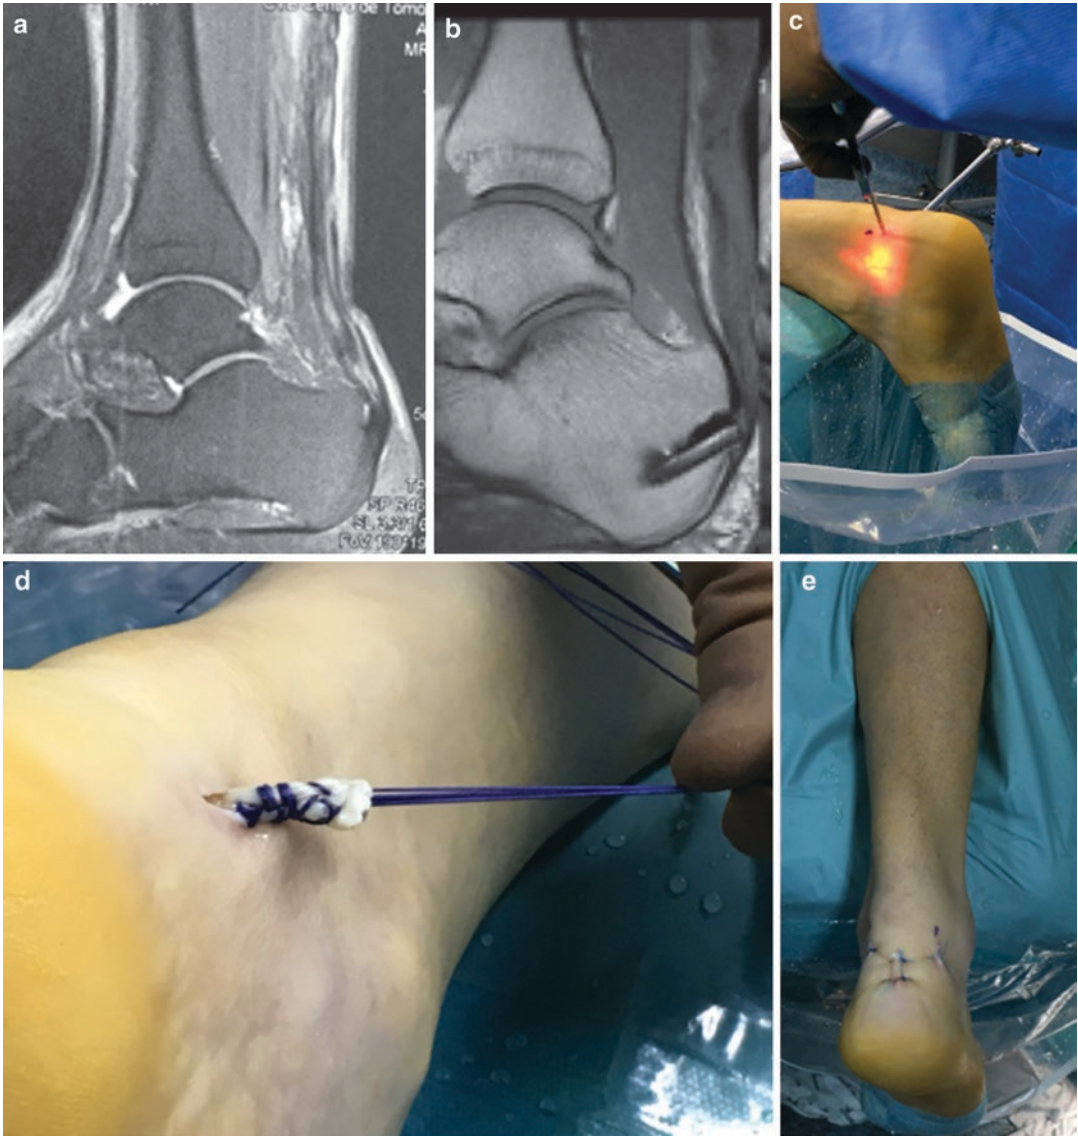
(a) MRI showing complex Achilles rupture; (b) MRI after Flexor Hallucis Longus Transfer (FHL); (c) Endoscopic approach; (d) the harvested FHL retrieved on
